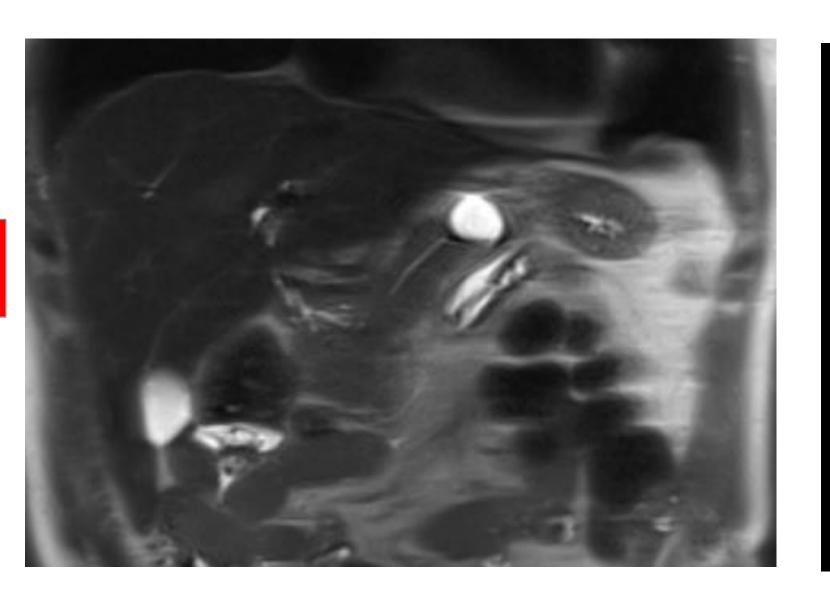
MRI Abdomen Pancreatic cyst.
